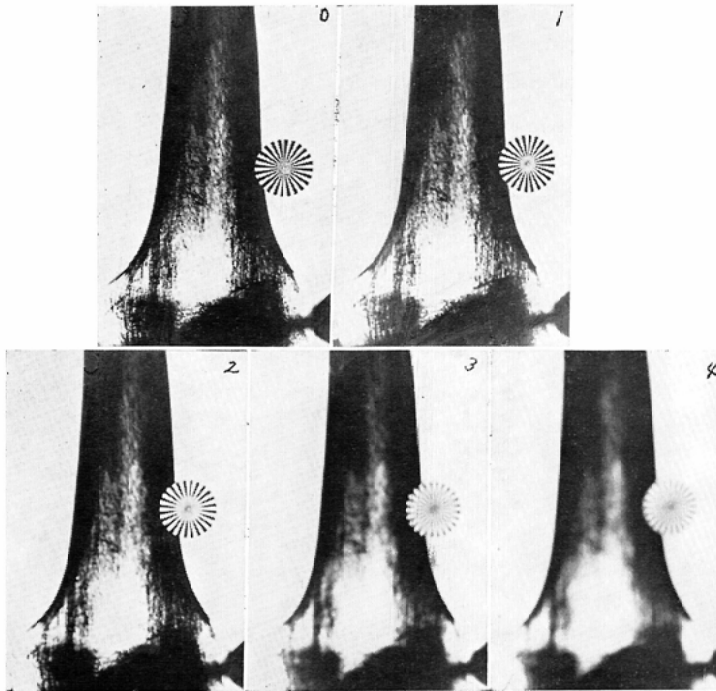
Several defocused photographs taken from the radiograph of the femur.
